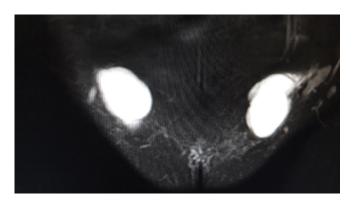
MRI of Case 1 showing bilateral hydrocele of canal of nuck.
